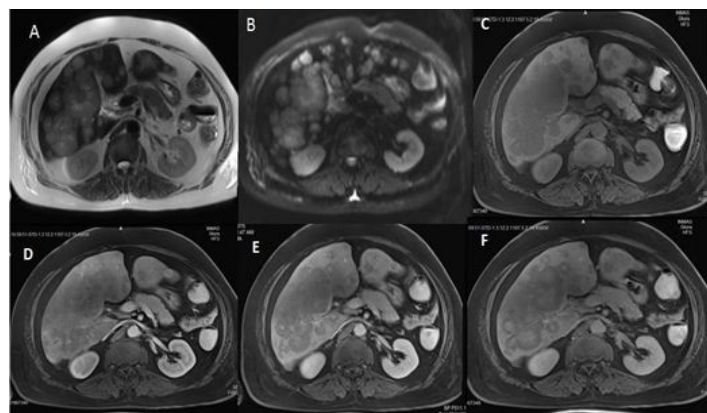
MRI of 56 year old male with bronchogenic carcinoma shows multiple hepatic metastases on (a) HASTE (half-Fourier acquisition single shot turbo spin echo), (b) DW (diffusion weighted) images, (c) non-contrast VIBE (volumetric interpolated breath-hold examination), (d) arterial phase, (e) portal venous phase and (f) interstitial phase contrast-enhanced images
